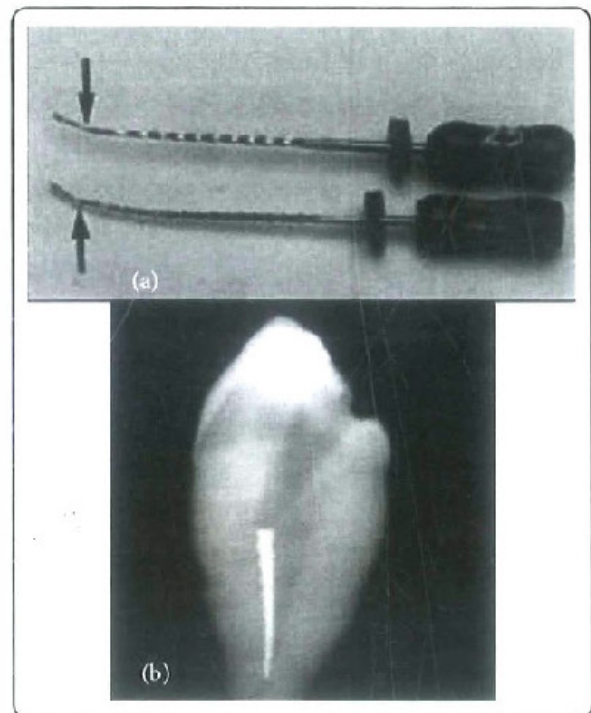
(a) Stressed instrument with unwound flutes, (b) A radiograph showing a separated instrument lodged inside the middle portion of the canal
